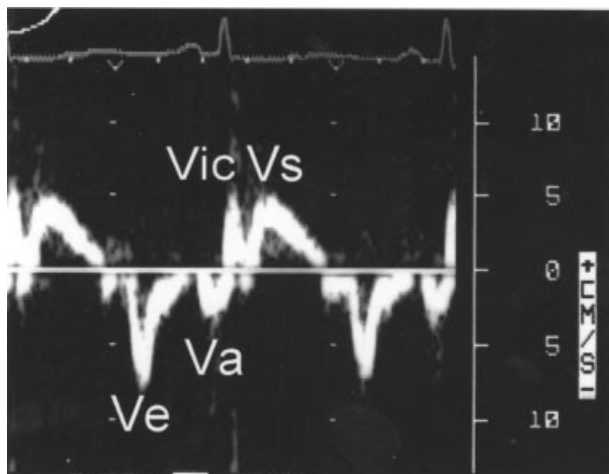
Pulsed-wave tissue Doppler recording of myocardial velocities in the LV anterior mid-wall. Systolic velocities are directed upwards (positive) and diastolic velocities are directed downwards (negative). V_{ic} =velocity of isovolumic contraction; V_s =systolic thickening velocity; V_e =early diastolic velocity; V_a =late diastolic velocity. The scale is set at $\pm 10 \text{ cm s}^{-1}$.
